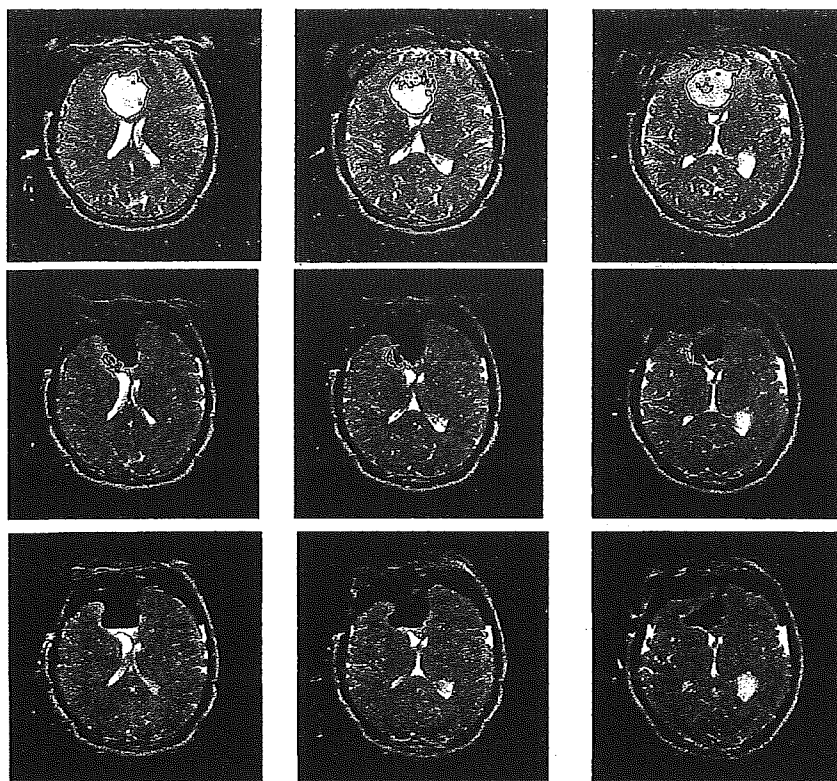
Intraoperative tumor segmentation in T2-weighted magnetic resonance imaging after dura opening (top row), initial tumor resection (middle row), and total resection of glioma (bottom row) in case 8. The images in each row are shown in the inferior-to-superior order. Note that the fuzzy connectedness-based segmentation clearly delineates the tumor and cyst boundary in the first scan (top row). In the second scan (middle row), 2.6 mL, or 6.2%, of the tumor (42.1 mL before the resection) was delineated by segmentation. No tumor was observed in the images obtained before dura closure (bottom row).
